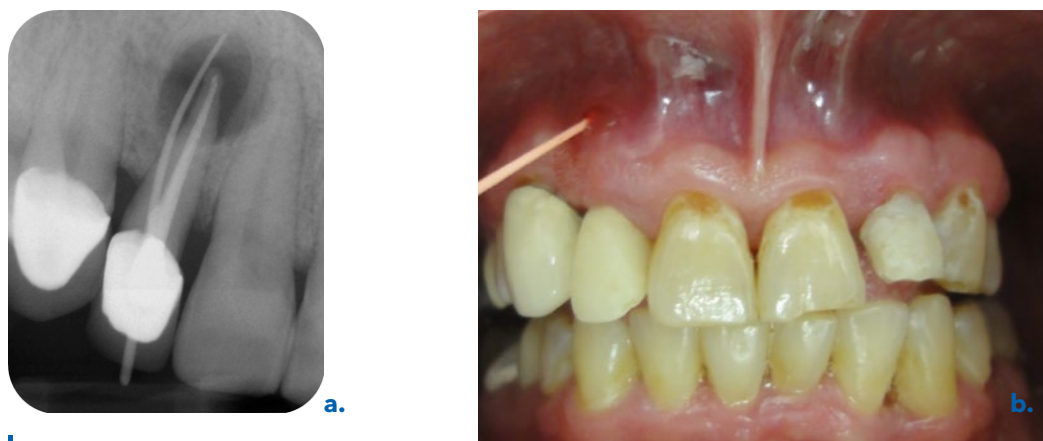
a. Radiograph and b. Photograph demonstrated maxillary lateral incisor tooth #12 with radiolucency and sinus-tract at the apical area
